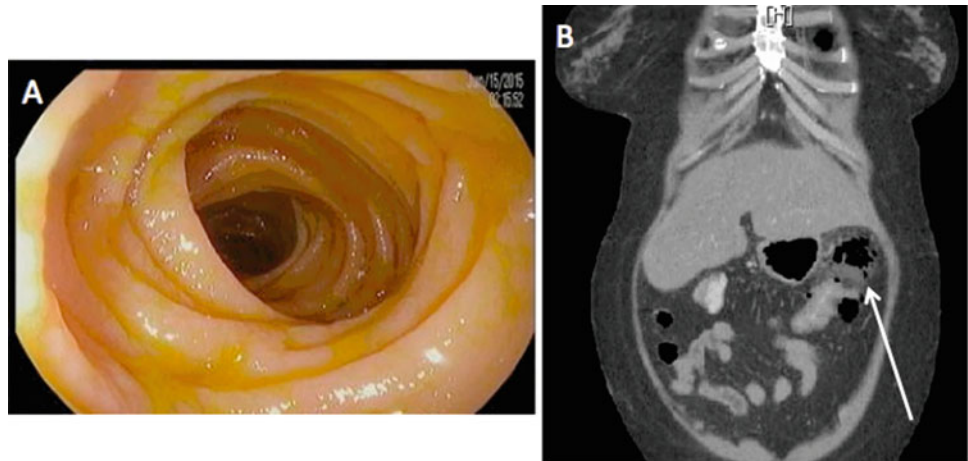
Perforation after therapeutic colonoscopy. Extraluminal air seen after argon plasma coagulation (APC) of a bleeding right colon arteriovenous (AV) malformation. On CT, there was no evidence of free
